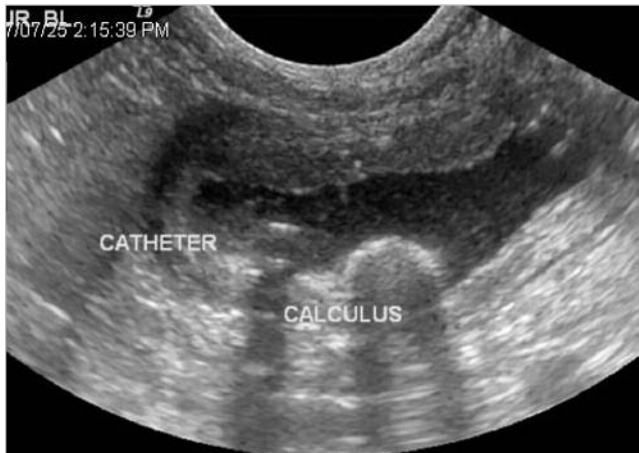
Abdominal sonogram of cystic calculus in urinary bladder. A large, hyperechoic (white) urolith is seen centrally with distal shadowing (dark). The tip of a urinary catheter with distal shadowing is seen in the apex of the bladder.
